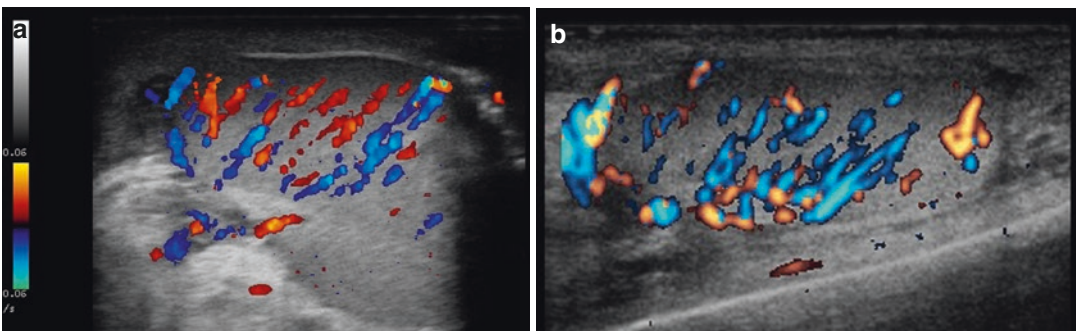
(a, b) Colour-power Doppler image of patient with epididymo-orchitis demonstrating increased flow. The tunica vasculosa is seen as lines of colour flow radiating from the mediastinum testis out to the periphery
